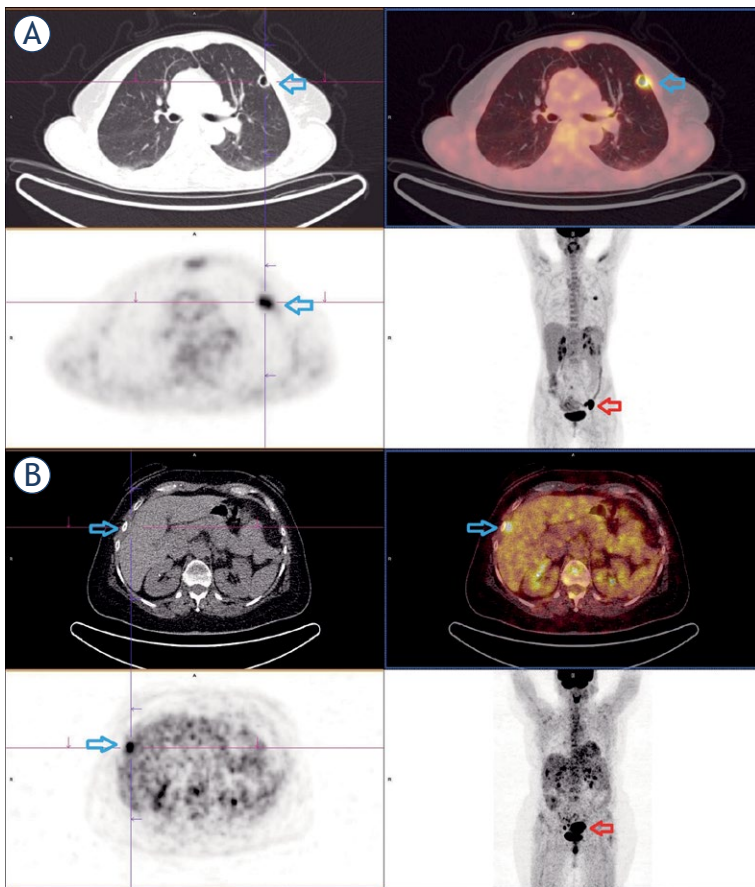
(A) A 51-year-old patient, with squamocellular carcinoma, presenting on FDG PET/CT with metastasis in left upper lung (blue arrow), and left iliac lymphadenopathy (red arrow). On MRI only left iliac disease was detected. (B) A 59-year-old patient, with adenocarcinoma, presenting on FDG PET/CT with active locoregional disease in pelvis (red arrow) also seen on MRI, and peritoneal deposit in front of the right liver lobe (blue arrow) which was missed by MRI.
